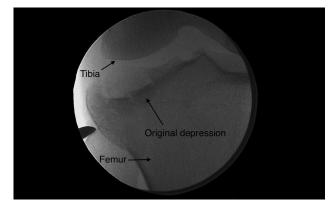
Intraoperative radiograph of the right knee, taken by C-arm, showing an intra-articular, 8-mm depressed lateral tibial plateau fracture.
